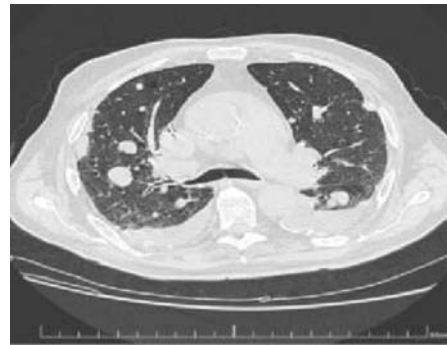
Thoracic CT scan showing lung metastasis.
